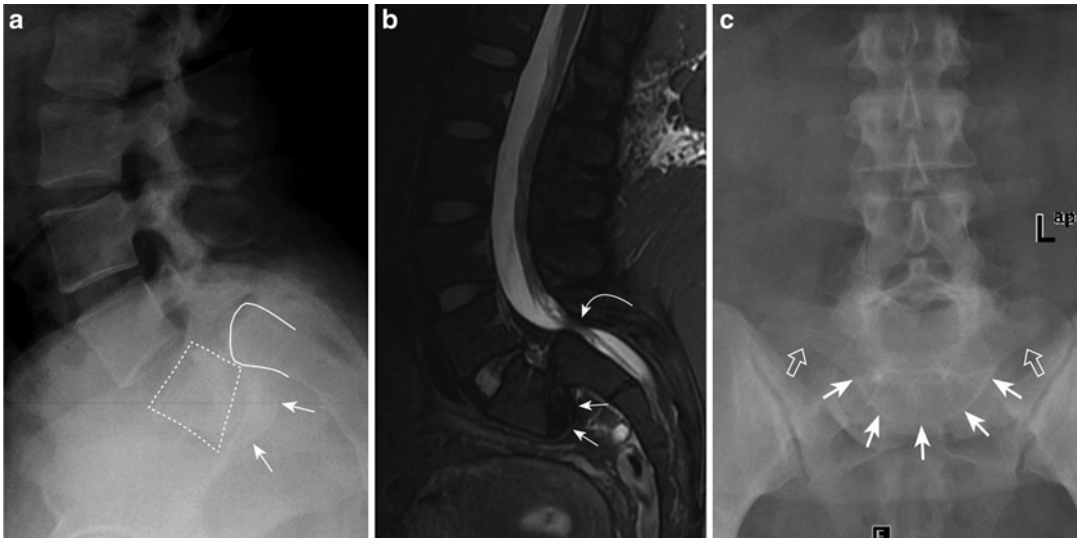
Spondyloptosis with inverted Napoleon's hat sign. (a) Lateral radiograph shows displacement of L5 (dotted lines) anterior and inferior to superior aspect of S1 (solid line). There is curved ossification at the inferior aspect of L5 (arrows). (b) Sagittal fat-suppressed T2W MRI shows marked central spinal canal stenosis (curved arrow). The dark low signal area beneath L5 (arrows) corresponds to the ossification demonstrated in (a) which
